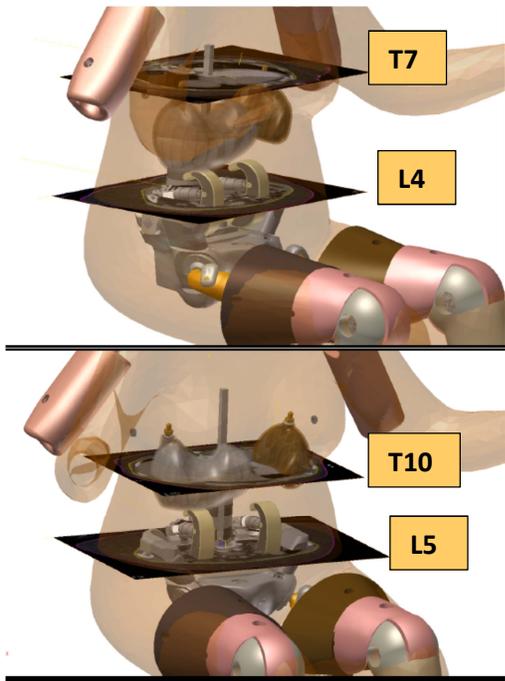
Overlay of ICAM MRI Scans into UMTRI Body Model
